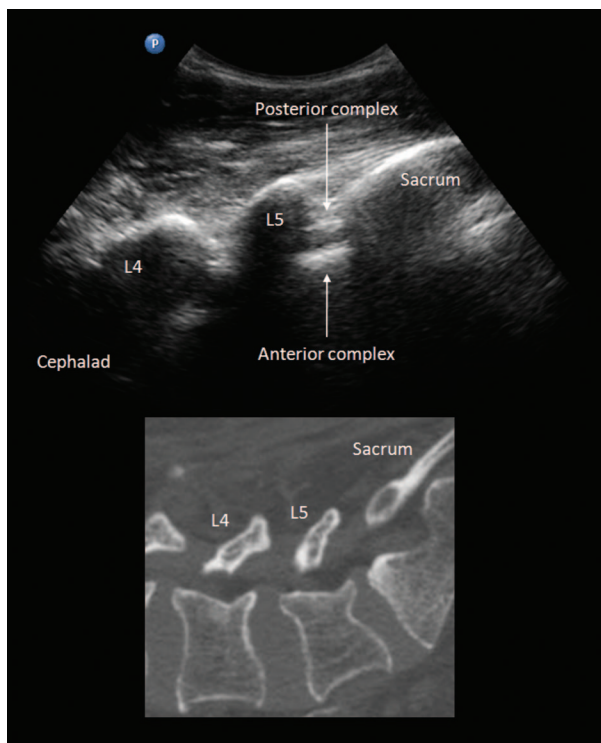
Paramedian sagittal oblique view of the L5–S1 junction and corresponding computed tomography image (bone window). The sacrum is recognizable as a horizontal hyperechoic curvilinear structure, and the L5 lamina has the typical “sawtooth” appearance. The structures of the vertebral canal are visible through the intervening gap. A distinguishing feature of the L5 lamina is its shorter superior-inferior width compared with the other lumbar vertebrae. (Image used with permission from www.usra.ca.)
